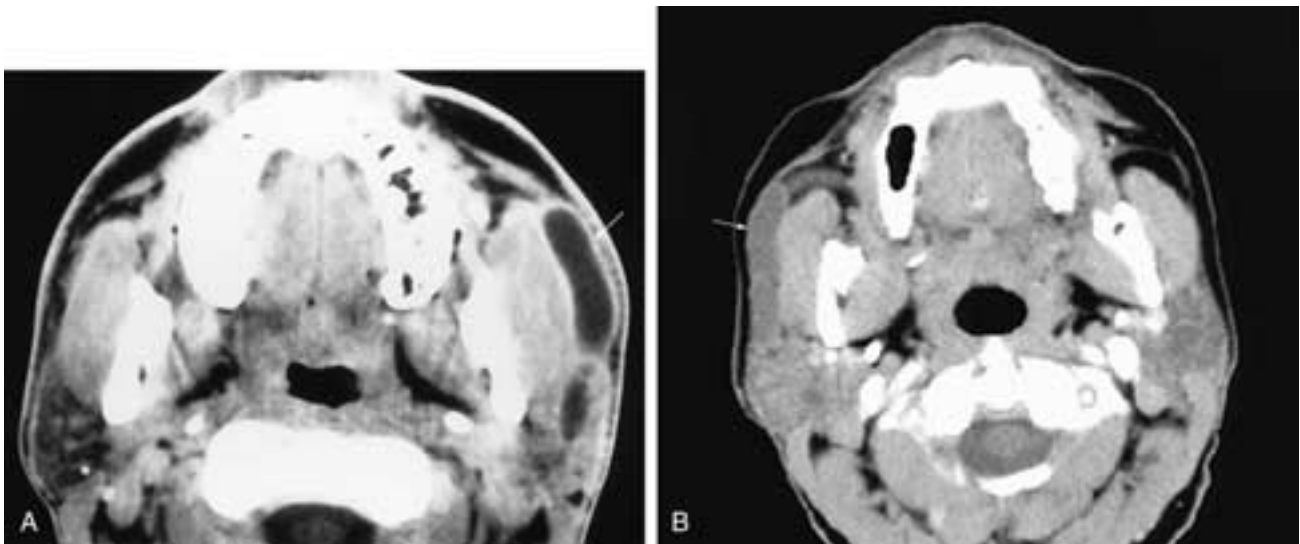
Axial contrast-enhanced CT scan (A) shows increased density in the left parotid gland, with enhancement and thickening of the walls of some intraglandular ducts and Stensen's duct (*arrow*). A small sialolith is present in the right parotid gland. Axial contrast-enhanced CT scan (B) in another patient shows mild generalized increased density in the right parotid gland and dilatation of Stensen's duct (*arrow*). Both of these patients had sialodochitis and sialadenitis.
